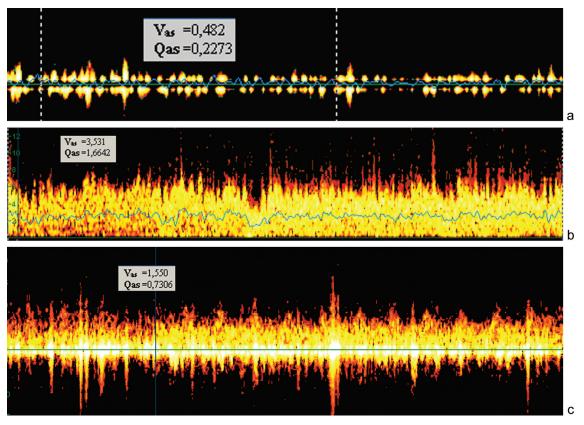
Dopplergrams of soft tissue perfusion. Intact limb (corresponds to the norm), Vas 0.1-0.8 cm/sec (a). Close to the traction units under distraction force, the capillary flow is increased by 350 % relative to the norm, Vas=3.53 cm/sec (b). Areas at the distance of 10 cm from the traction units, Vas 1.5 cm/sec (c). Capillary flow with a prevailing arterial component is increased by 50 % relative to the norm
